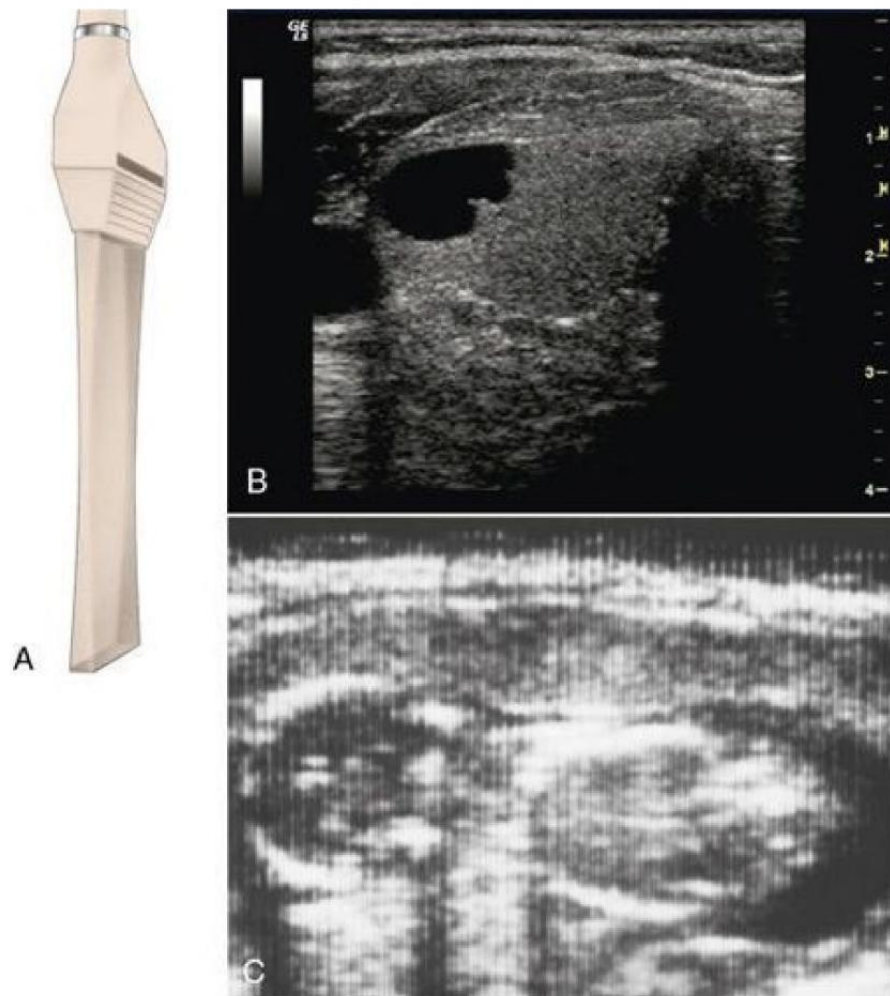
A, Ultrasound sent through a thin rectangular volume of tissue produces a rectangular image, commonly called a *linear image* or *linear scan*. B, Clinical linear (rectangular) scan. C, Poor-quality (by current standards) fetal image from the late 1970s, revealing the 120 vertical parallel scan lines of which it is composed.
